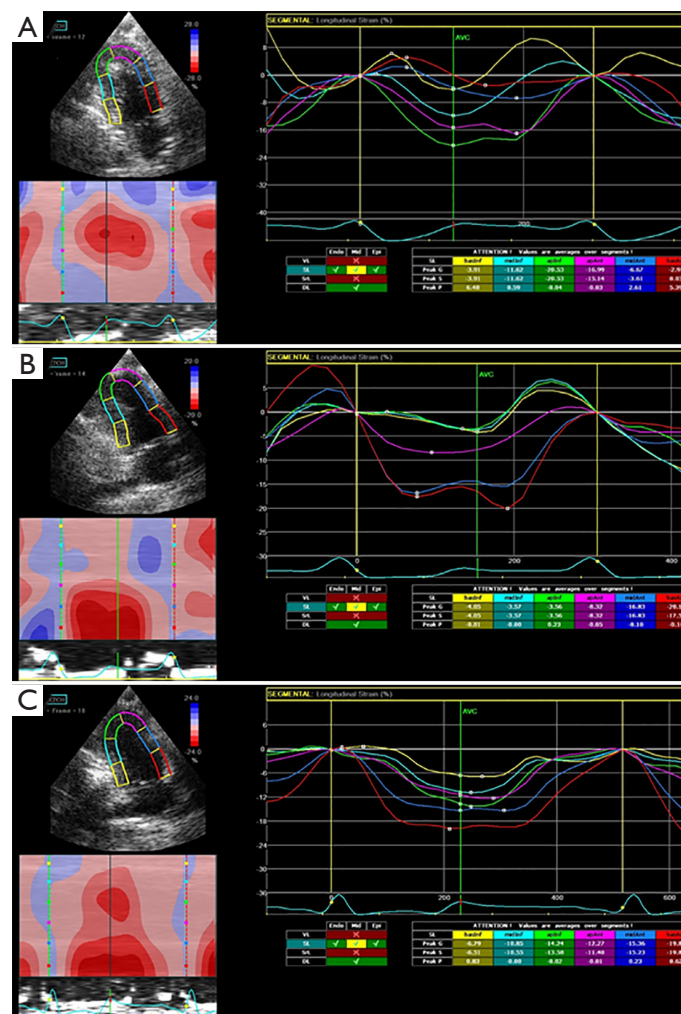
Two-dimensional speckle tracking echocardiography showed the left ventricular longitudinal strain curve of the apical 2-chamber section view. (A) All segments were disordered in motion in the myocardial infarction (MI) group, and the peak time was significantly different, suggesting that the myocardial motion is not in synchronization. (B) Coordination of each segment's peak time was slightly improved in the ultrasound-targeted microbubble destruction (UTMD) group. (C) Synchronization of each segment was significantly improved and tended to be consistent following UTMD-Ang1 treatment.
